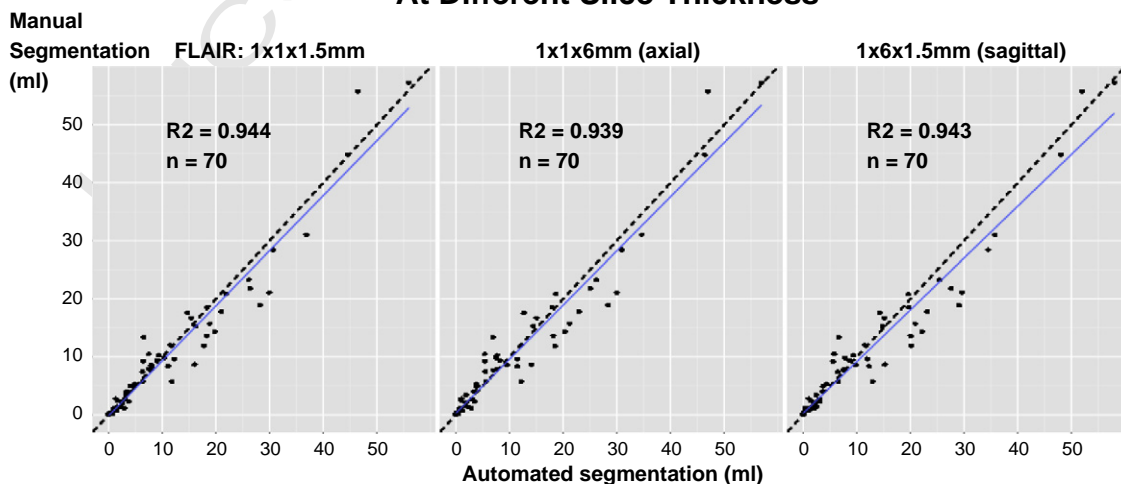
Manually traced lesion volumes are plotted over automatically segmented lesion volumes at different orientations and slice thickness of the FLAIR sequence. Data from 52 MS patients and 18 control subjects are included. The respective R2 values are given.
